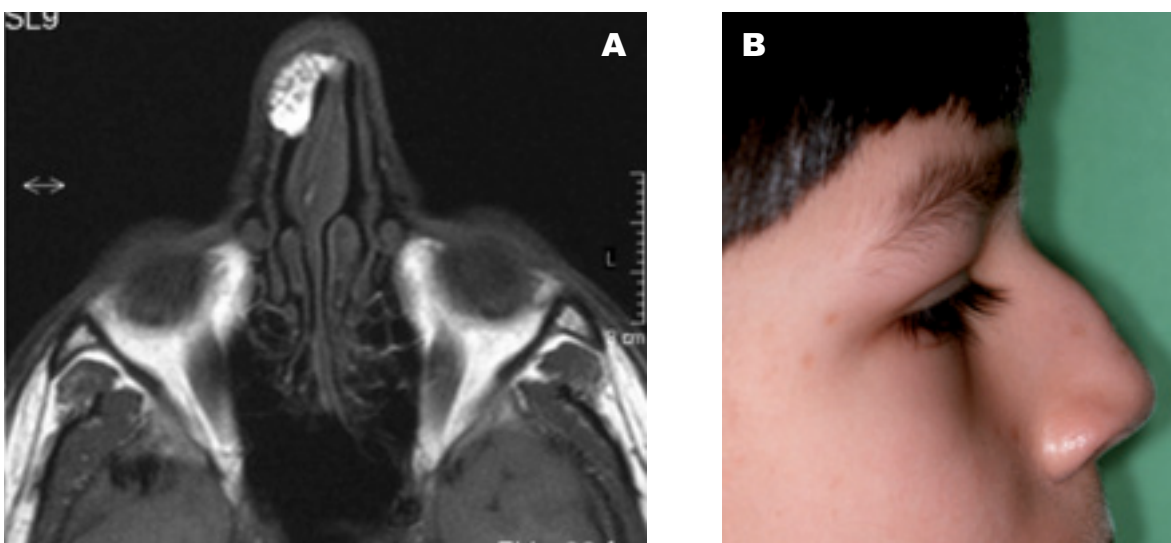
NDSC of the nasal dorsum A: MRI B: clinical appearance with disfiguring hump.
